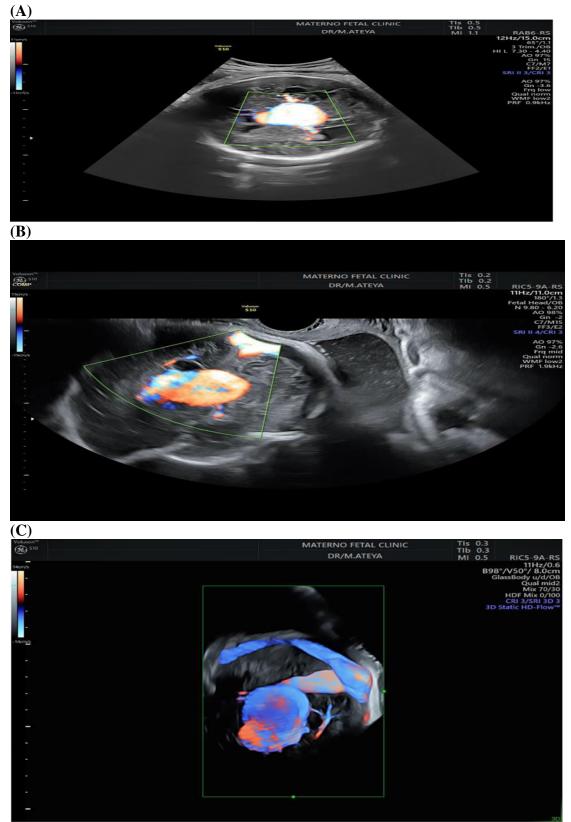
Two-dimensional ultrasound showing aneurysm in (A,B,C), all are Doppler colored .
